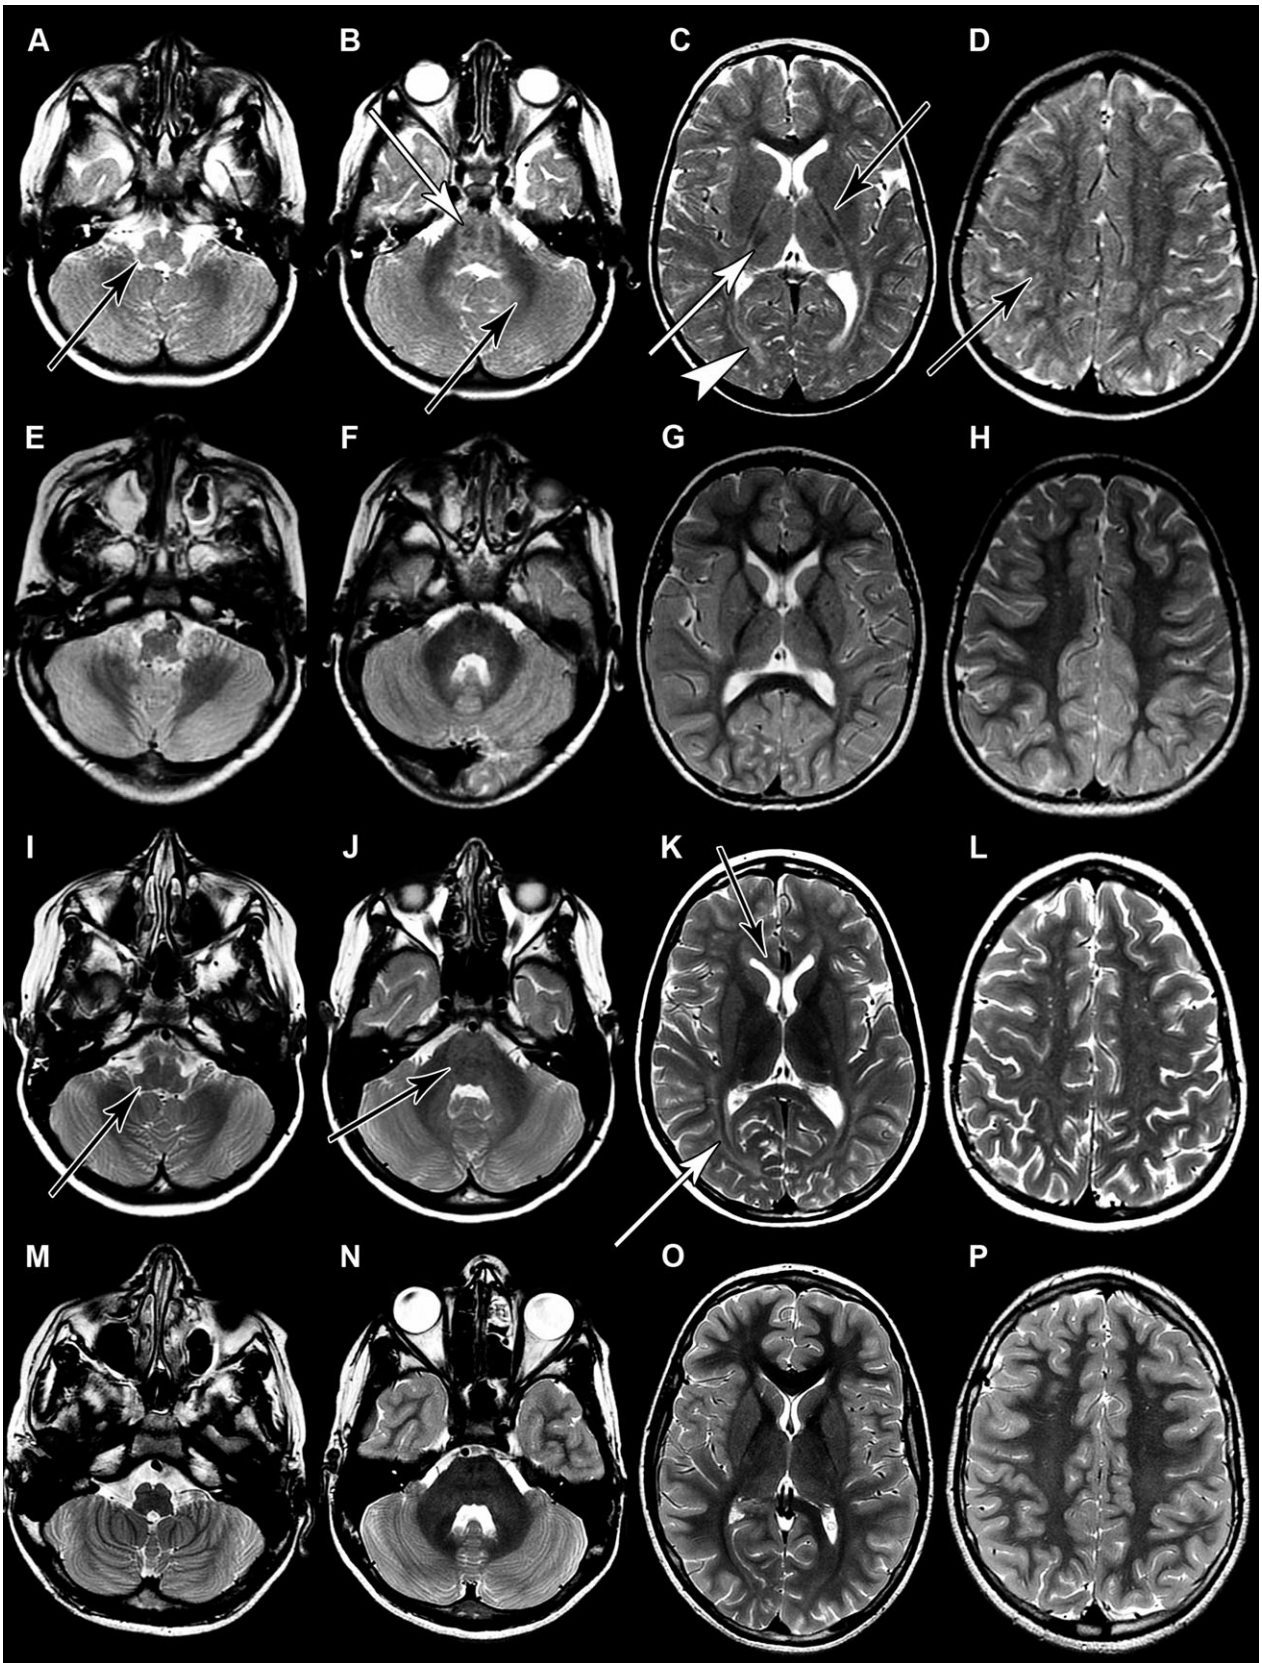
MRI of HEMS patients. Initial MRIs of patient 9 (A–D, age 3 years), and of an age-matched control (E–H, 2.5 years) and follow-up MRIs of patient 9 (I–L, age 12.4 years), and of an age-matched control (M–P, 12 years). All images are axial T₂-weighted. MRIs of patient 9 show mild T₂ hyperintensity of the medulla oblongata (A, arrow), the pons (B, white arrow) and the hilus of the dentate nucleus (B, black arrow). The thalamus is mildly T₂ hyperintense, except for its ventrolateral part, which is dark (C, white arrow). The posterior limb of the internal capsule shows alternating hyperintense–hypointense–hyperintense stripes (C, black arrow). There is mild T₂ hyperintensity of the optic radiation (C, white arrowhead) and the periventricular white matter that extends into the central subcortical white matter (D, black arrow). At later stages, the T₂ signal in the medulla and pons improves (I and J), but the T₂ hyperintensity of the optic radiation (K, white arrow), the corpus callosum (K, black arrow) and the periventricular white matter and subcortical white matter increases. Control images (E–H and M–P) show the normal myelination pattern with respect to age.
